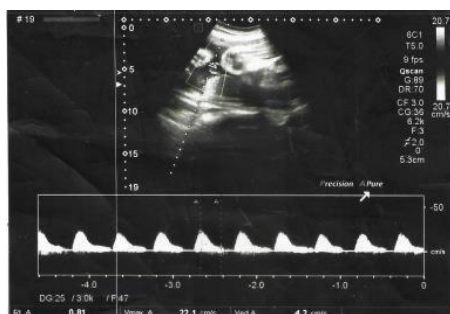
Umbilical artery Doppler showing decreased end diastolic flow (high resistance index).
